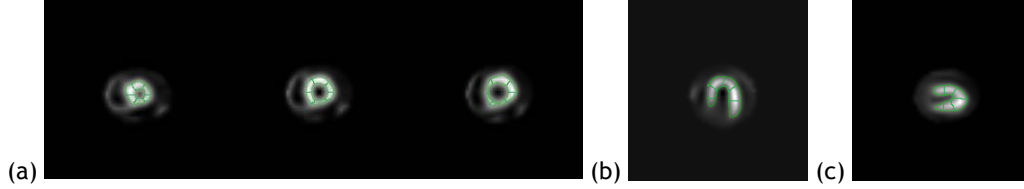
20-segments coronary artery mapping template SPECT for rest studies: (a) SA ; (b) HLA ; (c) VLA.
